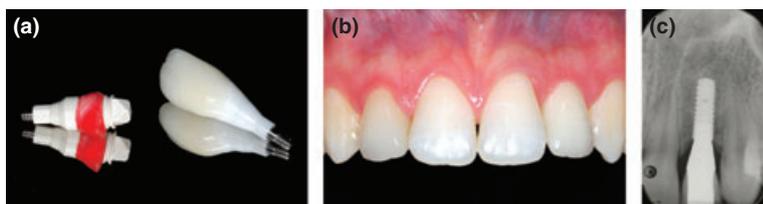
(a–c) Finalized 1-piece screw-retained ZrO<sub>2</sub> implant crown in comparison with the individualized scanbody (a), the clinical situation with the final restoration in position 22 (b) and the corresponding intraoral radiographic condition (c).
